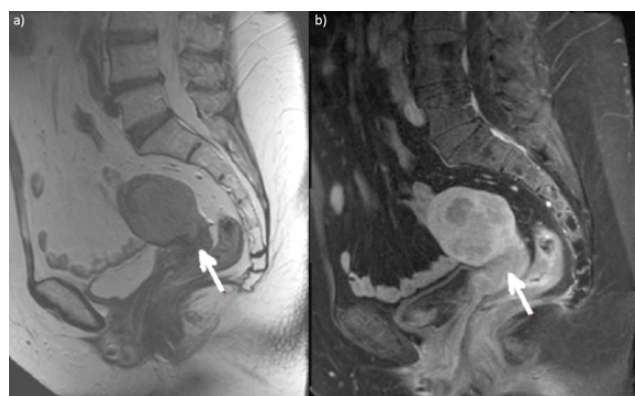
Pelvic MRI: a) T2W and b) T1W C+ images show cervical stromal invasion without a clear distinction between epithelium and stroma (arrows) (stage II).
